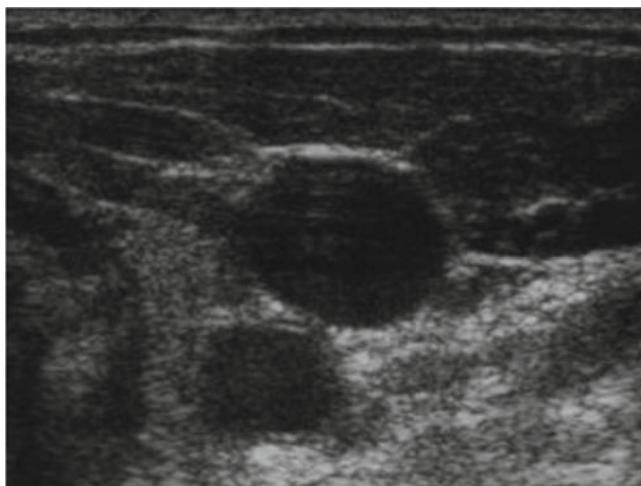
Ultasonographic transverse view of internal jugular vein (*above*) and common carotid artery (*below*)
